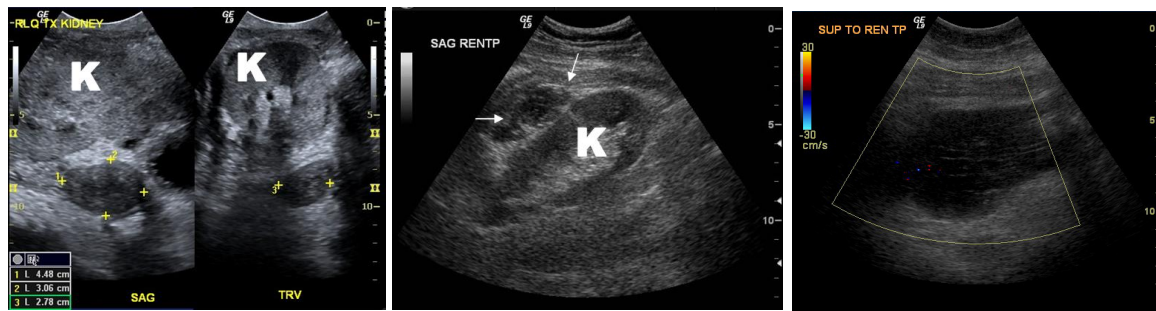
Post-surgical hematomas. (A), a dual image (sagittal and transverse) through the transplant kidney shows a well circumscribed solid appearing hematoma (calipers) posterior to the kidney (K). (B) shows a hematoma (arrows) seen as complex fluid collection anterior to the kidney (K). (C), a color Doppler image through a large hematoma which is mostly avascular.
